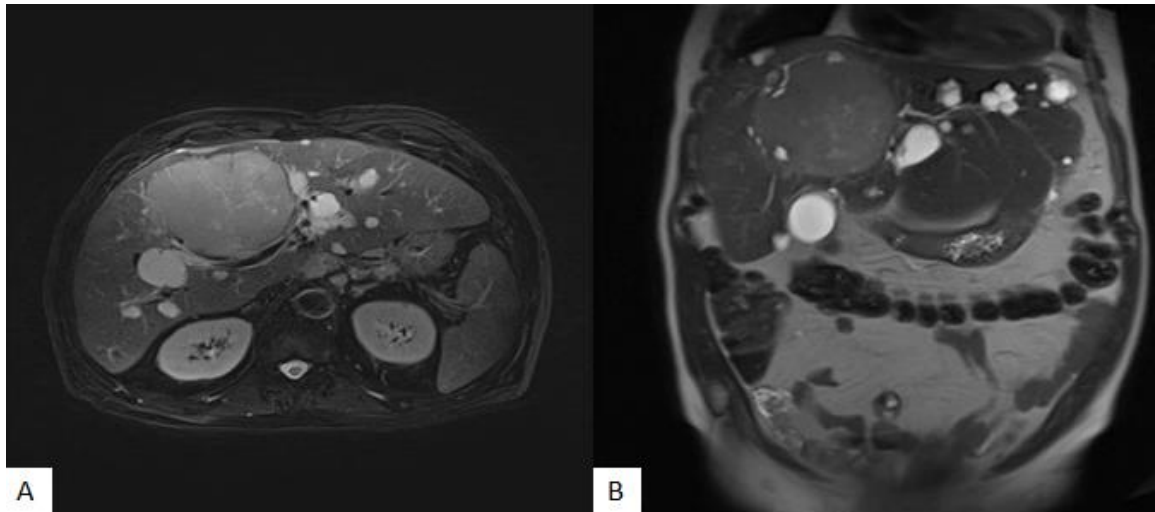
Liver MRI in axial T2 sequences (A) and coronal T2 (B) showing the presence of a tissue mass in segment IV with multiple cystic lesions of the liver
